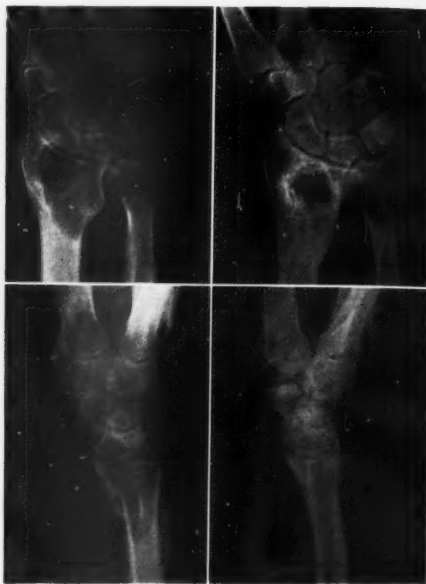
Case 7: Giant-cell tumor of lower end of radius before and fourteen years after two curettements and roentgen therapy. Some bone defects still present.
